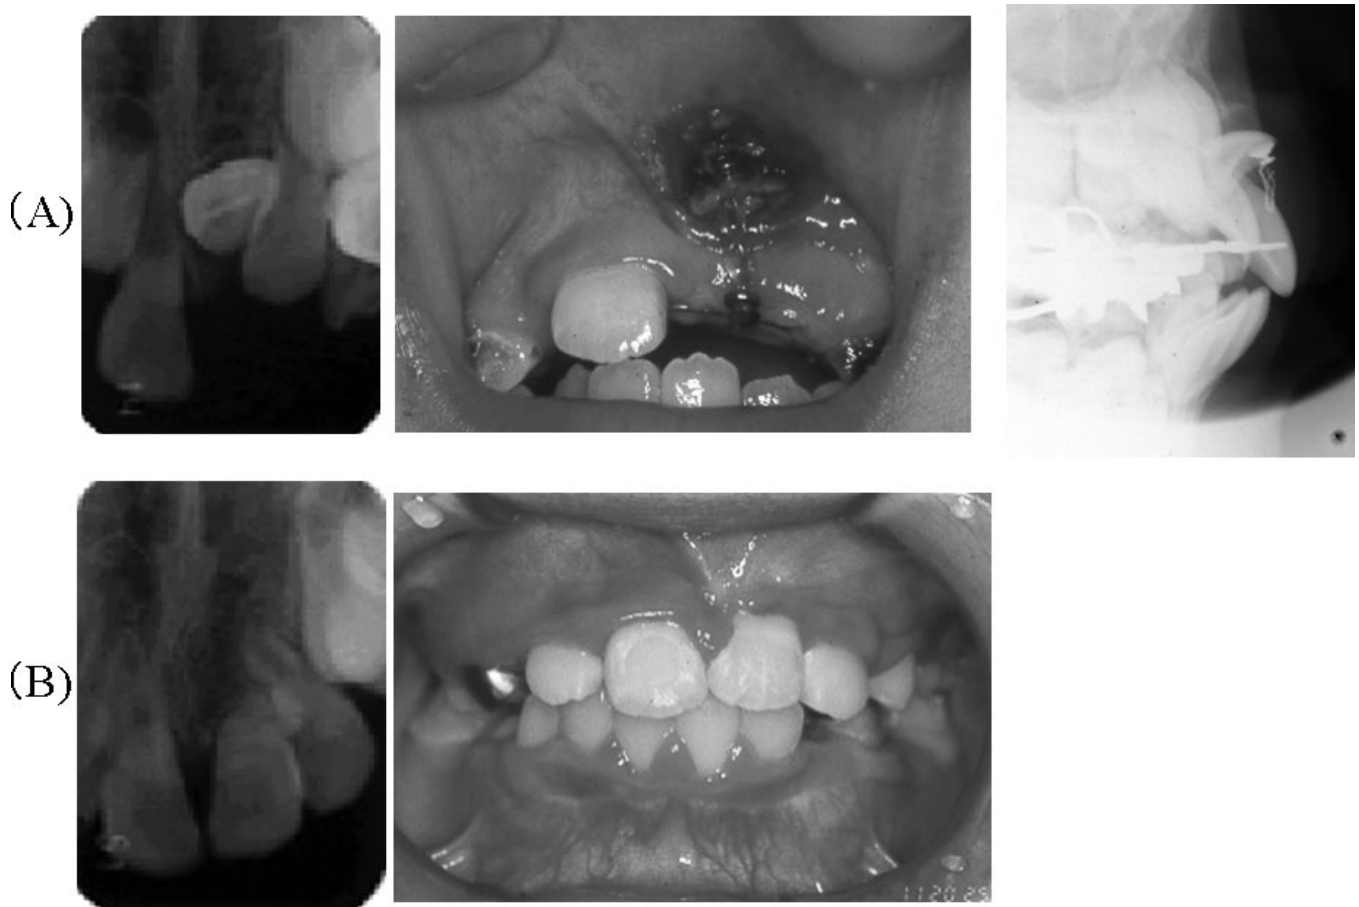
Periapical and occlusal radiographs before tooth traction and intraoral photograph at surgical procedure.
